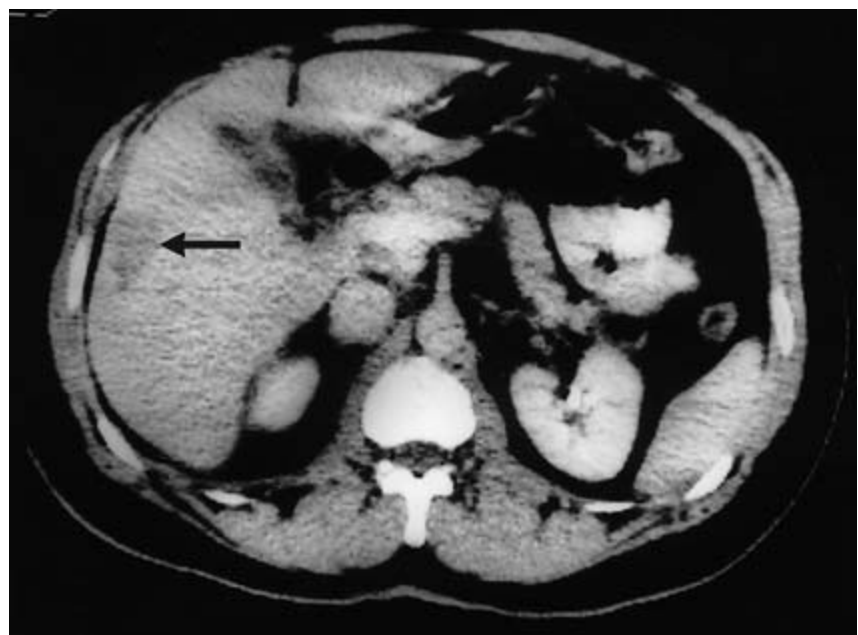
Contrast-enhanced CT scan shows hypodense lesion in the right lobe of the liver (arrow).
